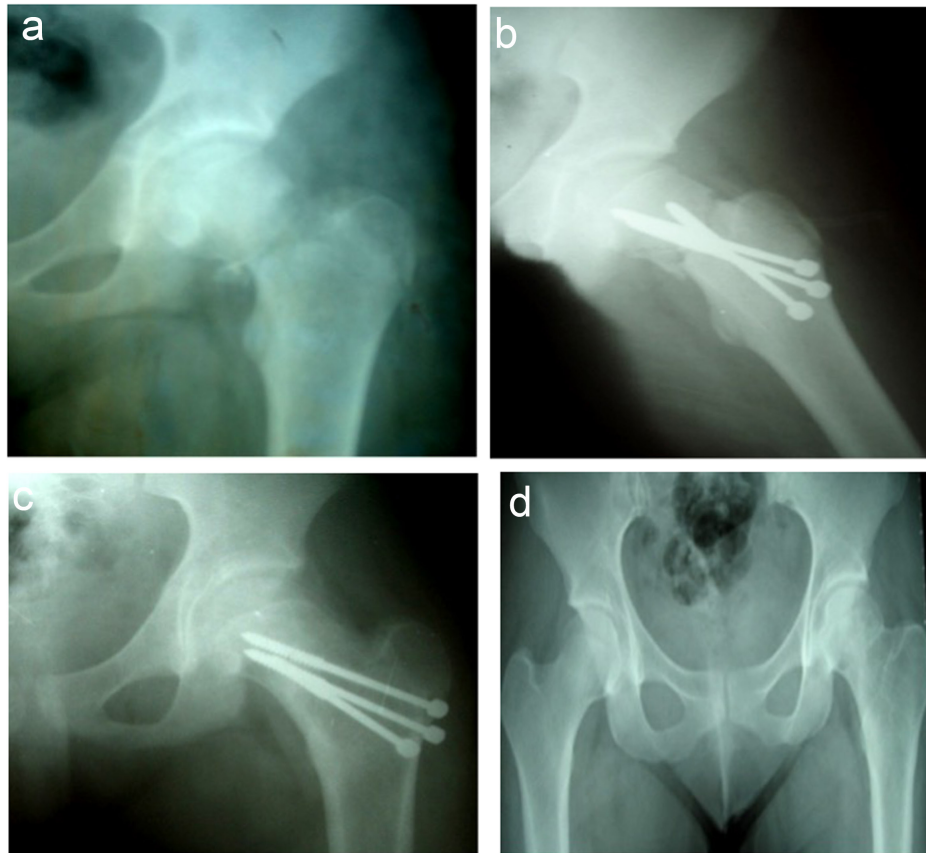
a-d. Anterior-posterior view (AP) radiograph of an 11-year-old girl with a displaced femoral neck fracture (a) and lateral view after open reduction and fixation with Knowles pins. (b) AP view of the patient at postoperative 2 years follow-up and (c) AP view at skeletal maturity(d).
